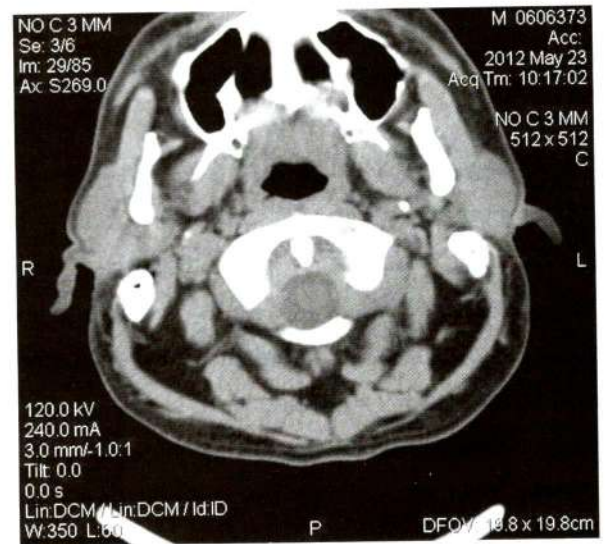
Axial non-contrast CT scan showed excessive fat filtration at posterior cervical space.
